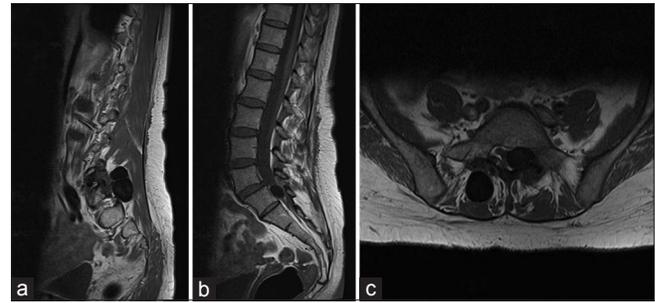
Preoperative MRI scan in sagittal (a and b) and transverse plane (c) showing intraspinal and paraspinal masses at levels L5 and S1
